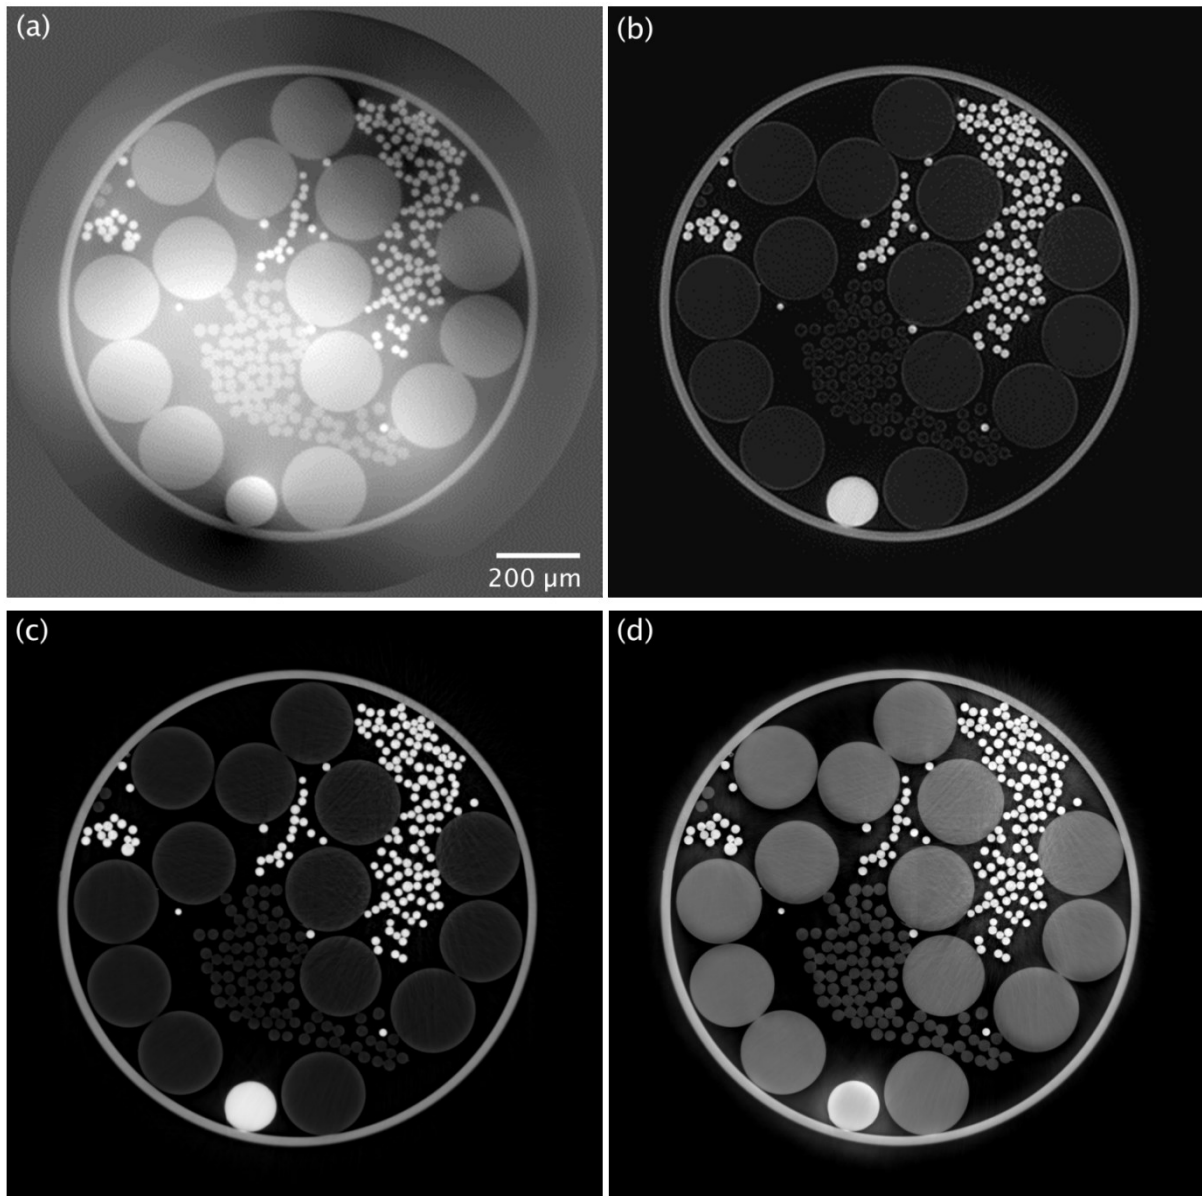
Reconstructed slices of the test object constructed from fibers of Al, Al₂O₃, PP and PET. X-ray energy: 22.5 keV, pixel size: 0.7 μm, propagation distances: $d = [2, 10, 20, 45]$ mm. (a) Using the mixed approach (b) Mixed approach with homogeneity prior ($\delta/\beta=367$, set to Al), (c) Paganin's method ($\delta/\beta=367$, set to Al) and (d) the method described above using the attenuation index reconstruction for prior of the phase retrieval. (reprinted from (Langer et al., 2014))
